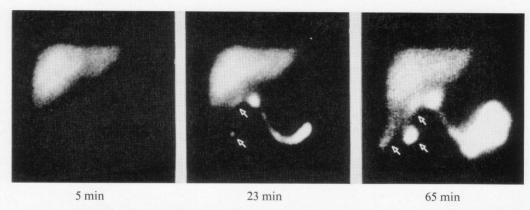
Case 1 (patient 26). Representative hepatobiliary scintigram of a patient with biliary leak (arrows) after liver transplantation.
